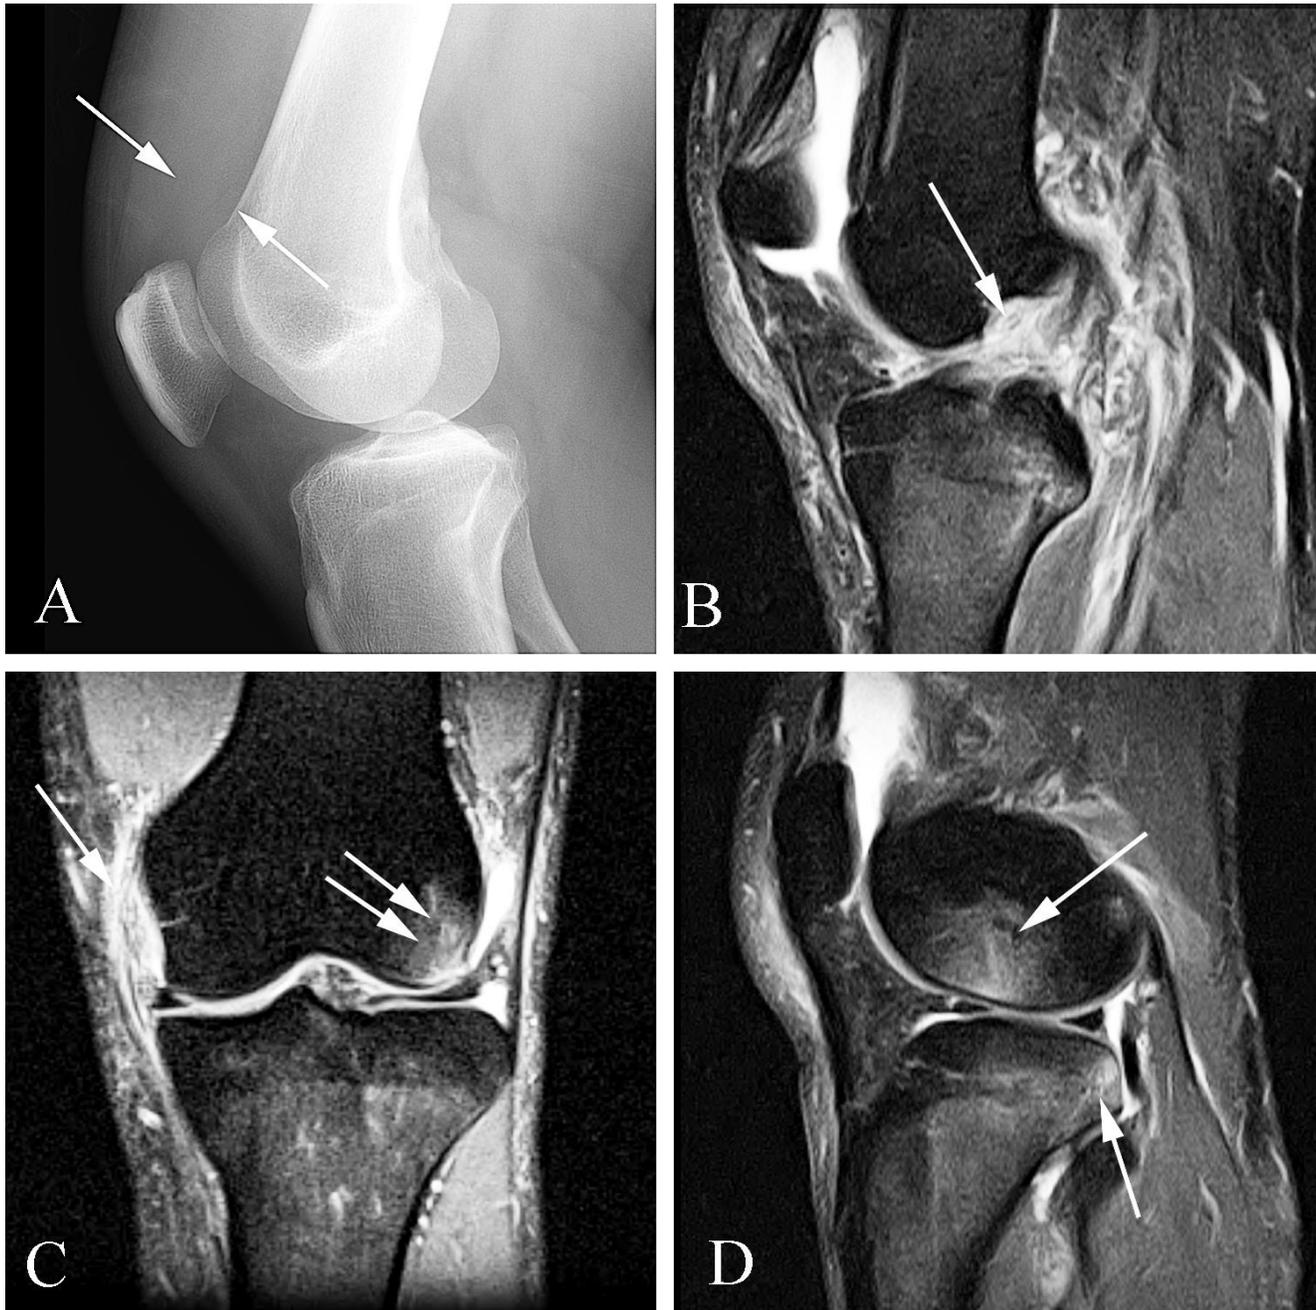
Knee effusion with associated ACL and MCL tears in a 33 year old man with knee pain. A. Lateral plain film shows fullness in the suprapatellar bursa (arrows), nearly always indicating a knee joint effusion. B. Sagittal fat-suppressed T2 weighted image demonstrates discontinuity of the anterior cruciate ligament (ACL) (arrow) secondary to an ACL tear. C. Coronal fat-suppressed proton density image demonstrates a tear of the proximal medial collateral ligament (MCL) (single arrow) along with abnormal increased signal in the lateral femoral condyle (double arrow) from bone marrow contusion. D. Sagittal fat-suppressed proton density image demonstrates so-called “kissing contusions” (arrows) of the lateral femoral condyle and posterior tibial plateau created by the pivot-shift injury which caused the patient’s ACL and MCL tears.
